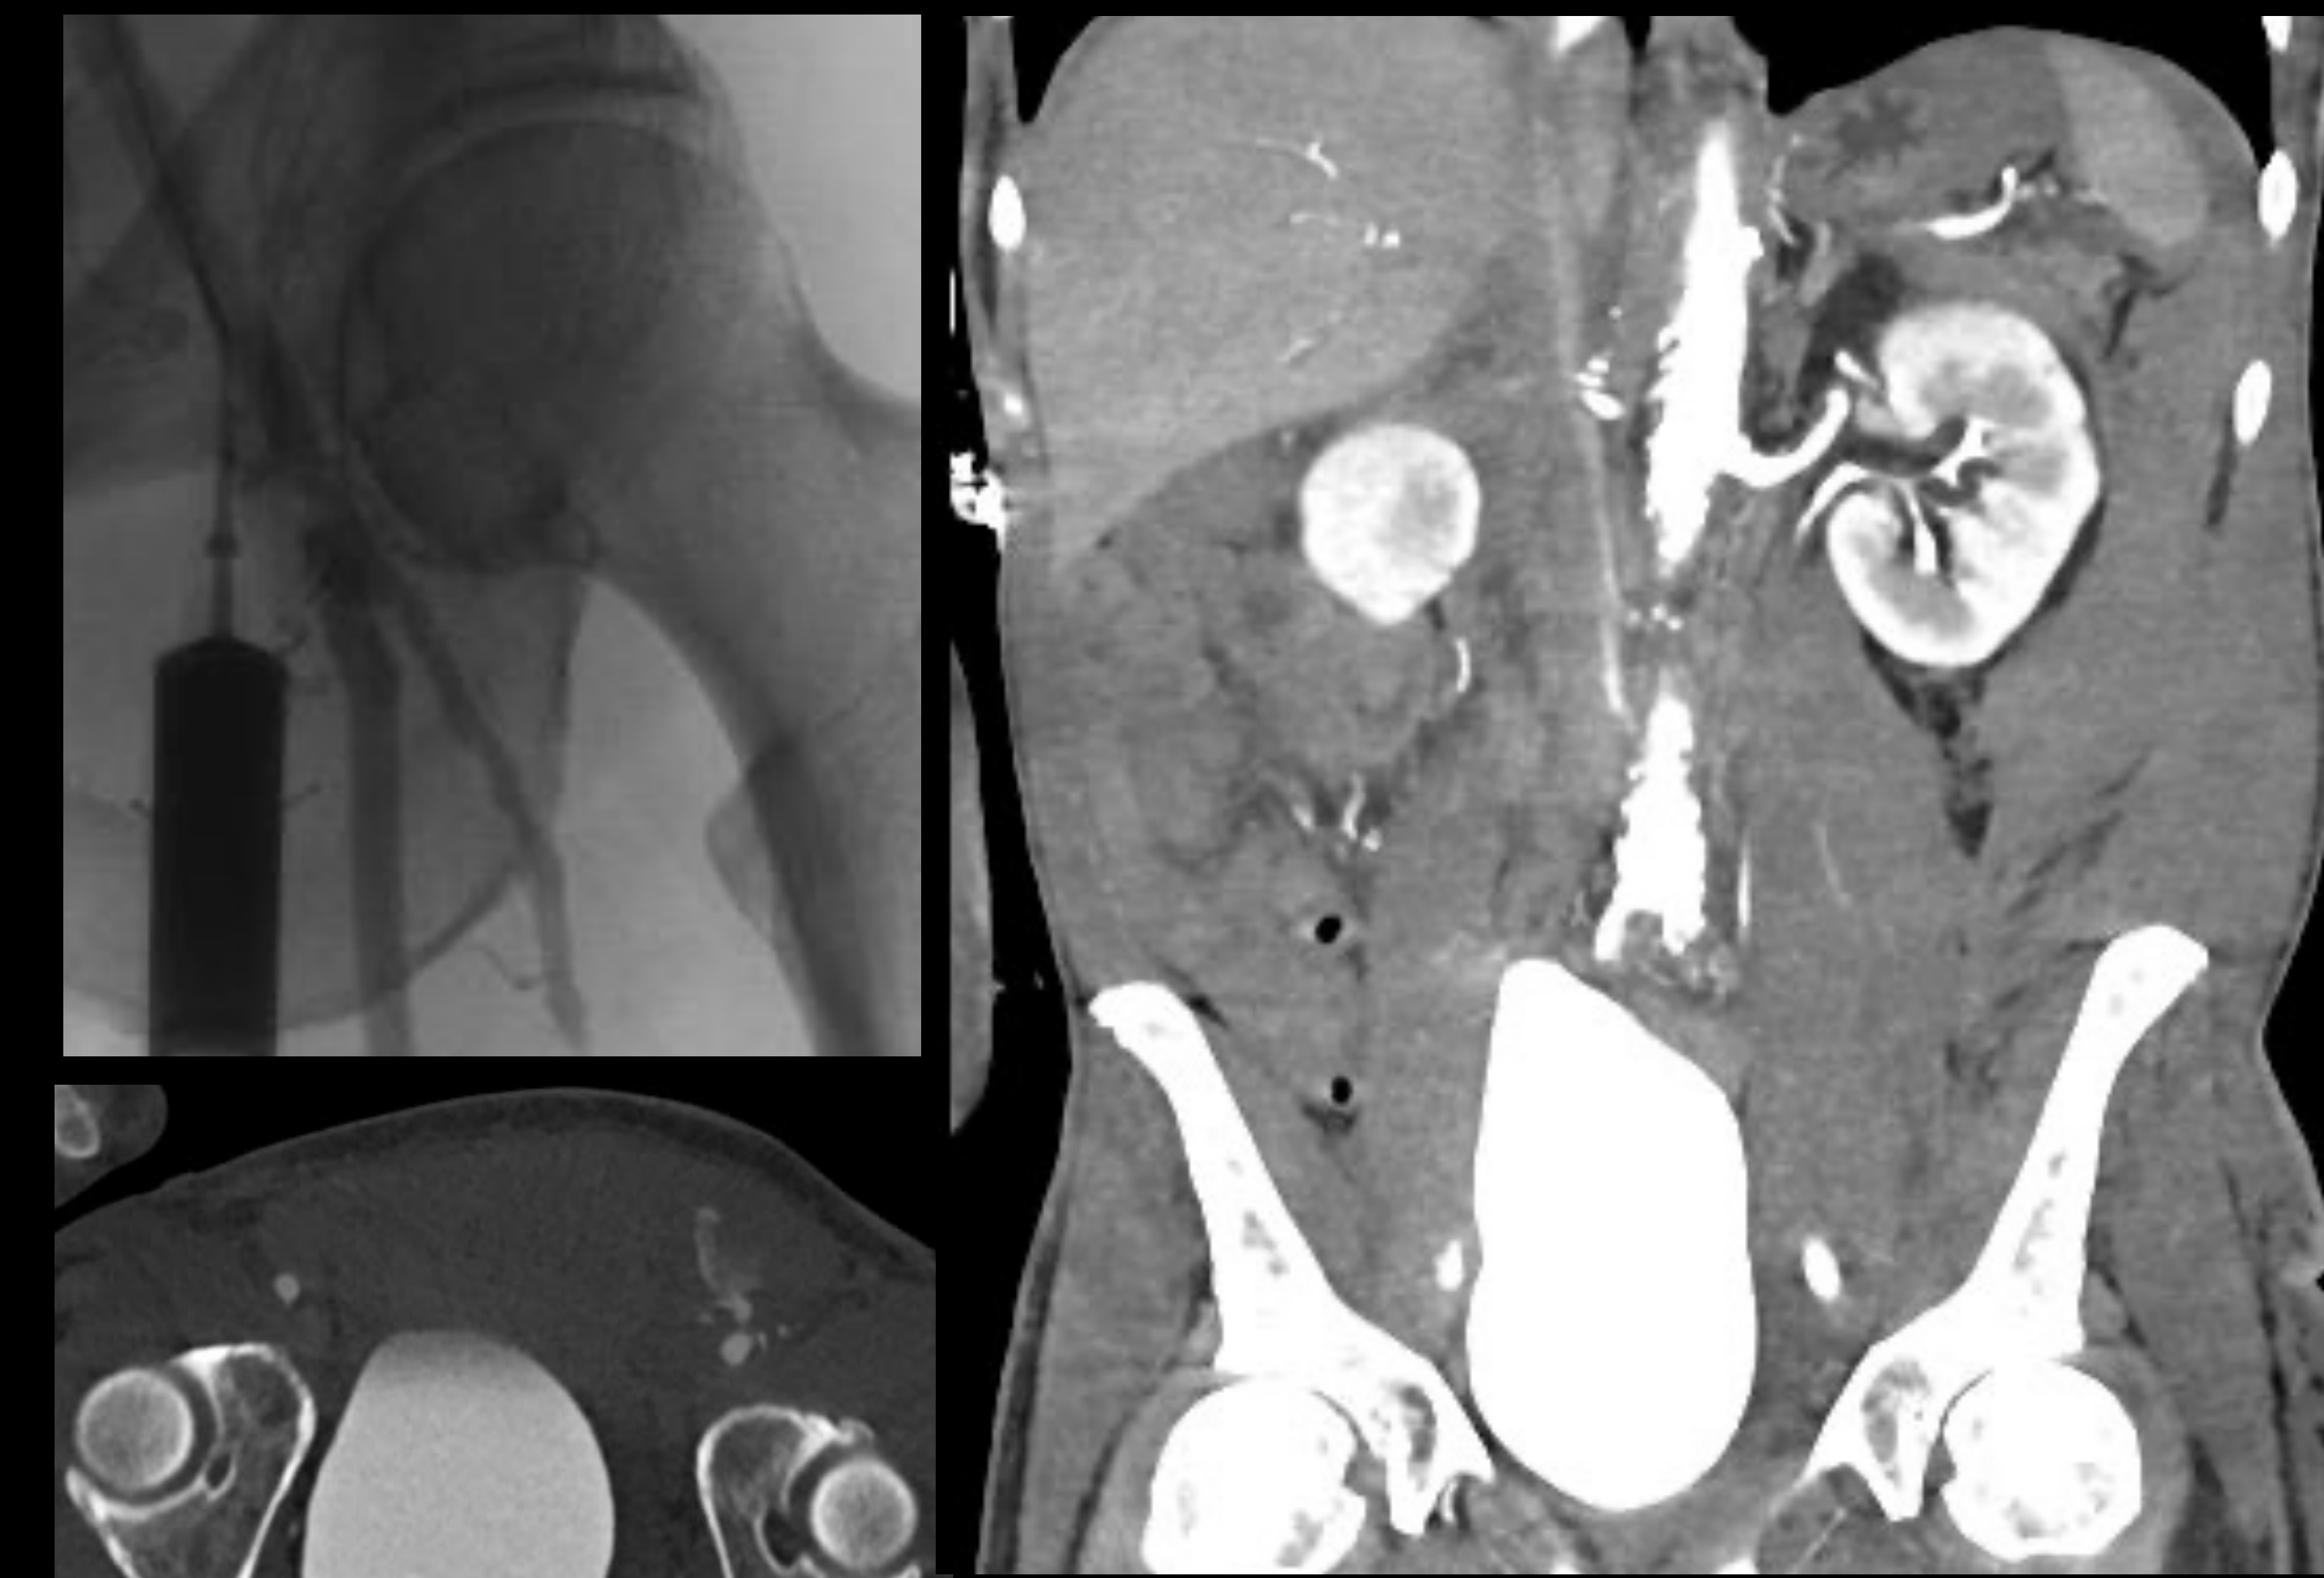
Ipsilateral femoral angiogram. Figure 3B, 3C: Left CFA extravasation and retroperitoneal hematoma on CT angiogram performed after the patient decompensated post-operatively. This patient had a prior left fem-pop bypass.
